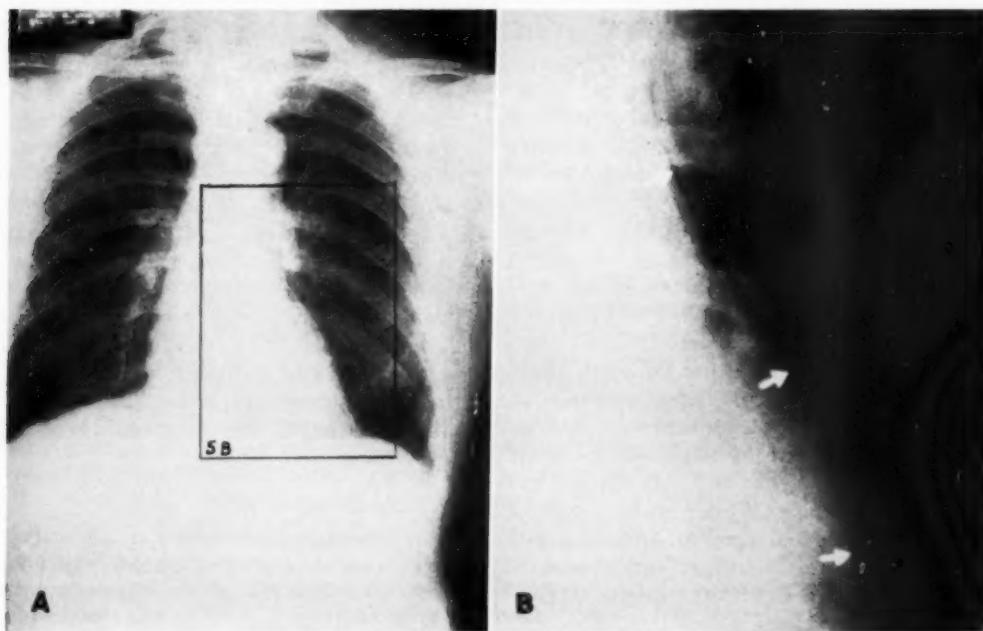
A. Roentgenogram of chest of a 72-year-old male, demonstrating the normal subepicardial-pericardial shadow pattern. A linear shadow of increased density seen along the right heart border is believed most probably to have been produced by a superimposed pulmonary vascular shadow. B. Enlarged reproduction of indicated segment in 5A.
